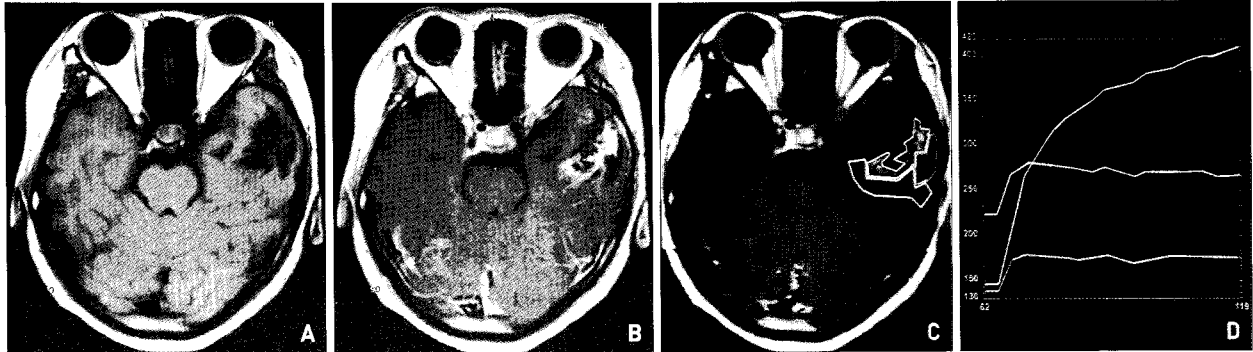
Magnetic resonance images of the brain and dynamic scan were taken on the enhancing and surrounding areas in 22-year-old female patient with ganglioglioma in the left temporal lobe (case 12). A : T1-weighted axial image. B : Enhancement with Gd-DTPA. C : Region of interest for enhancing (yellow) and 2 surrounding (white and red) areas. D : Dynamic scan on the enhancing area shows "T pattern" (yellow) and those on the surrounding areas show "E pattern" (white and red).
